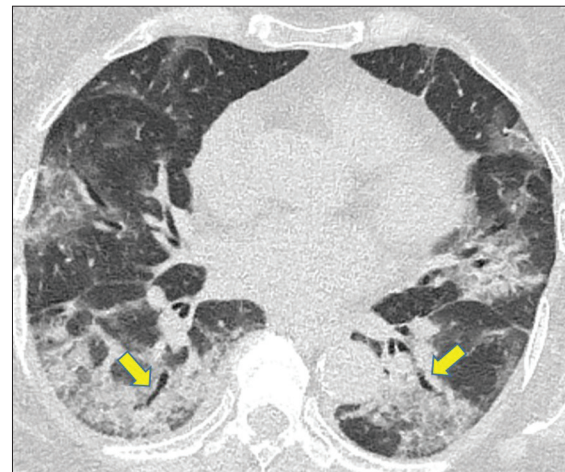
A 77-year-old female coronavirus disease 2019 patient presenting with fever and with cough for 7 days. A computed tomography scan revealed a bilateral air bronchogram in the lower lobe (yellow arrows)
